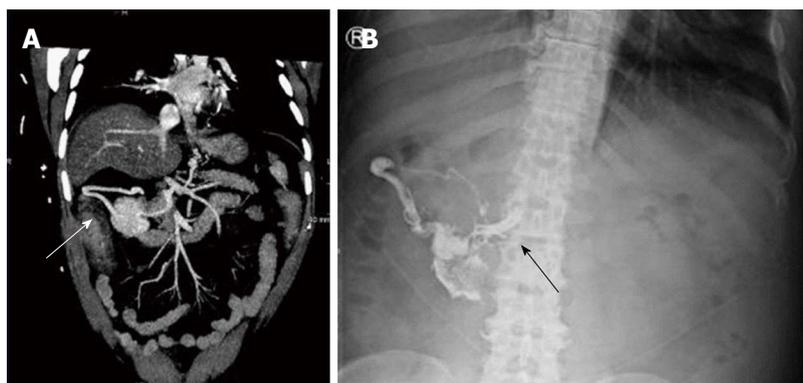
Duodenal varix on computed tomography and plain radiograph before and after glue injection. A: Computed tomography angiogram showing a large abdominal varix meeting the duodenum (white arrow); B: After glue injection a plain radiograph showed lipiodol/glue in the same vessel, with extension medially up to the portal vein (black arrow).
